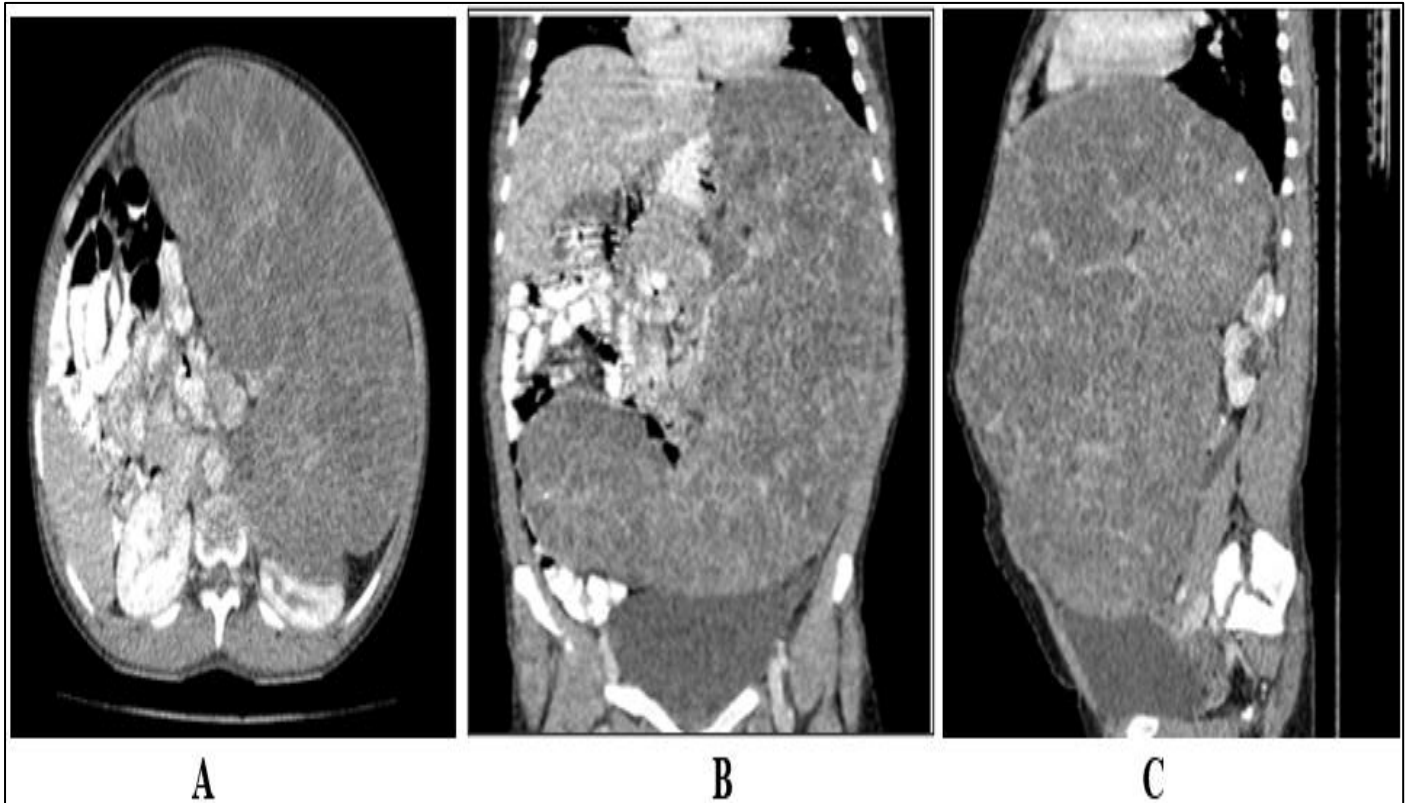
(A) Axial, (B) Coronal, (C) Sagittal sections. Contrast enhanced CT Abdomen showing enlarged spleen with multiple non-enhancing hypodense lesions & calcifications in splenic parenchyma seen compressing left kidney.
